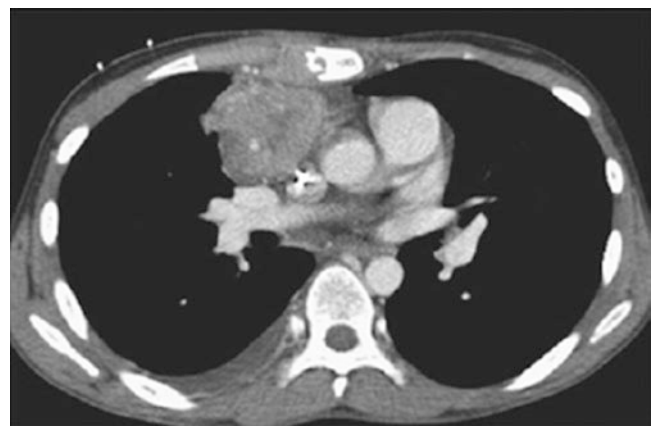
A 6-year-old girl with thymic carcinoma who presented with chest pain. Enhanced axial CT image shows a heterogeneous mass in the anterior mediastinum with irregular borders and chest wall invasion, including sternal destruction
